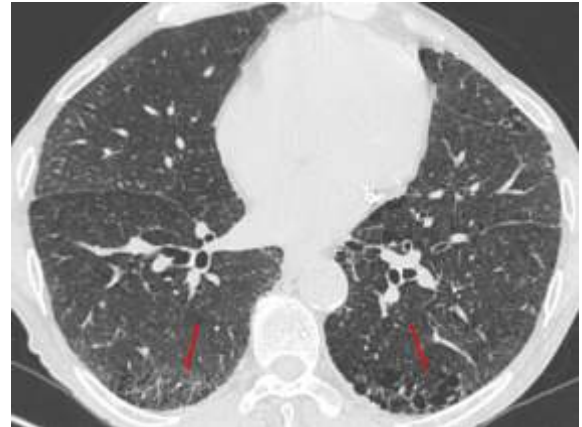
Smoking related interstitial fibrosis (SRIF). Axial CT through the superior segments of the lower lobes shows reticular opacities with traction bronchiectasis, suggesting SRIF.
